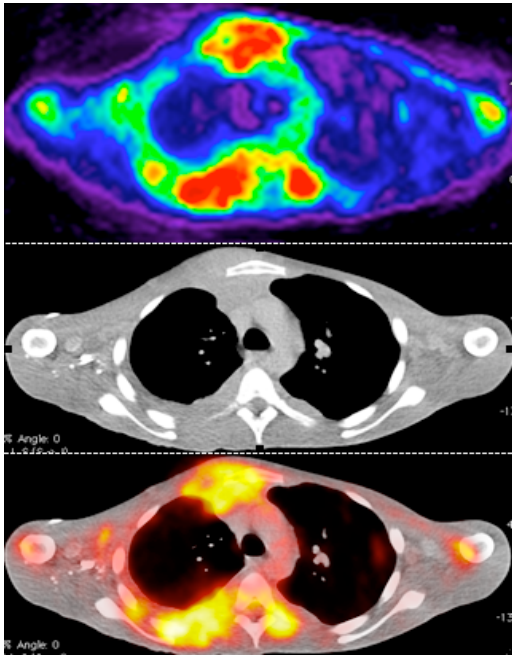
A 28 yr old man with a large right-sided pleural effusion and Mycobacterium Tuberculosis on pleural fluid analysis. Dual-time point imaging was performed at 60 min and 120 min following IV administration of 224.59 MBq (6.07 mCi) of ^{68}Ga -citrate and IV contrast. Intense tracer accumulation was noted in the anterior chest wall and posterior thickened pleura on the right. (SUVmax₁ 7.42; SUVmax₂ 7.17; decrease of 3.4 %) Liver SUVmax: 3.90
